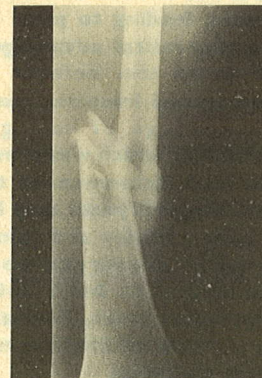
Preoperative radiograph of comminuted fracture shaft of femur.
